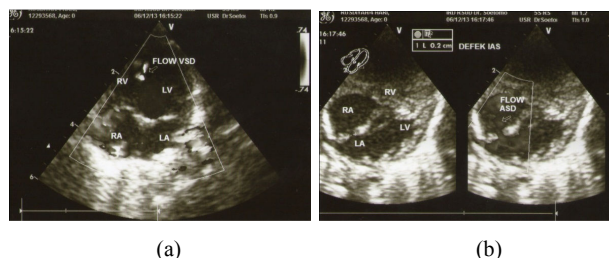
Echocardiography of the first baby showed: (a) VSD and (b) small ASD
